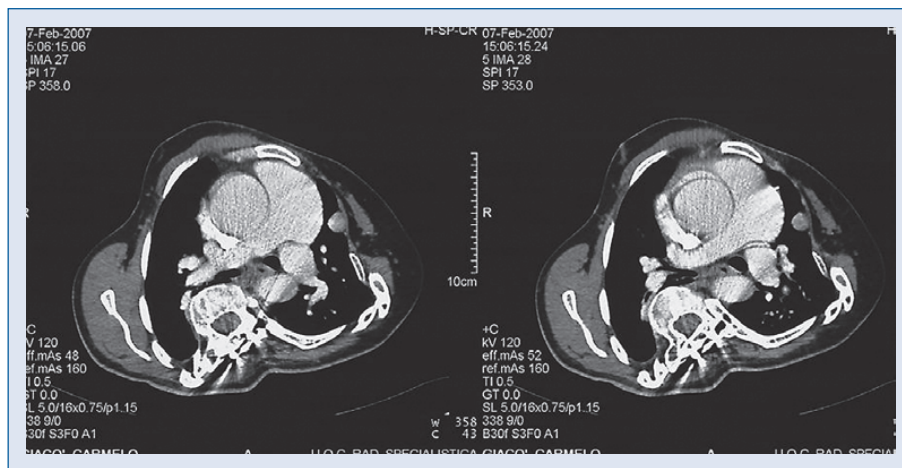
Computed tomography scan showing — dilated ascending aorta and pulmonary artery, and hypoplastic left chest including hypoplasia of the left lung.
